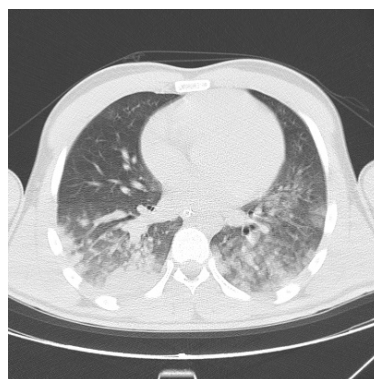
On axial CT examination there was pneumonic consolidation and infiltration dominantly in lower lobe
